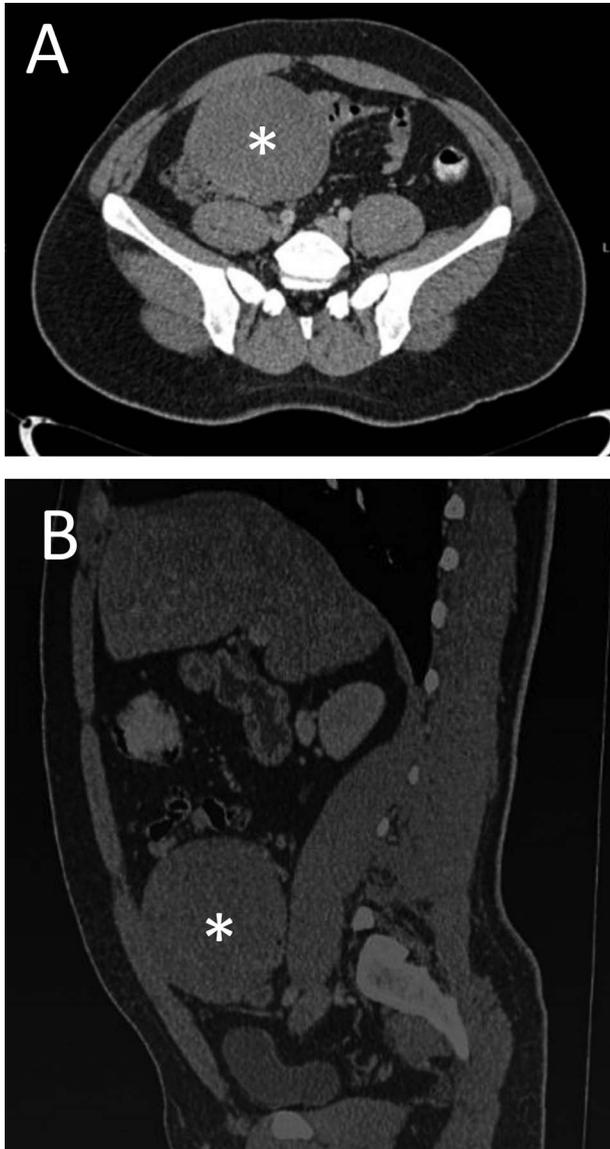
(A) Axial CT image shows homogenous mass (*) extending anteriorly abutting the posterior margin of the right rectus abdominis muscle. (B) Sagittal CT image of the homogeneous soft tissue mass (*) in the right iliac fossa with specks of fat within it.
